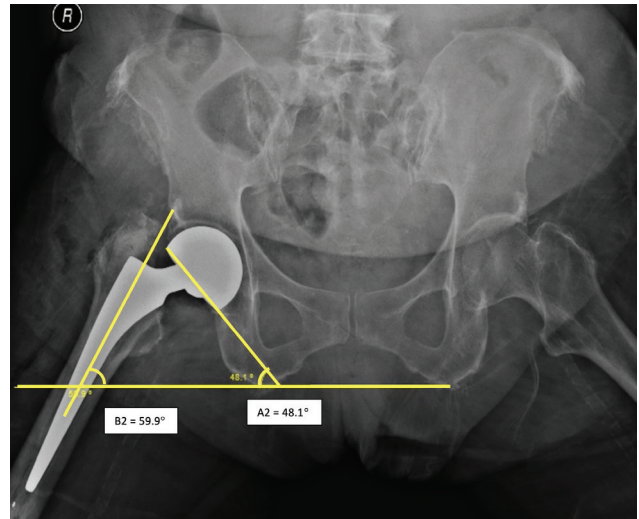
Hip maximum abduction AP x-ray.
